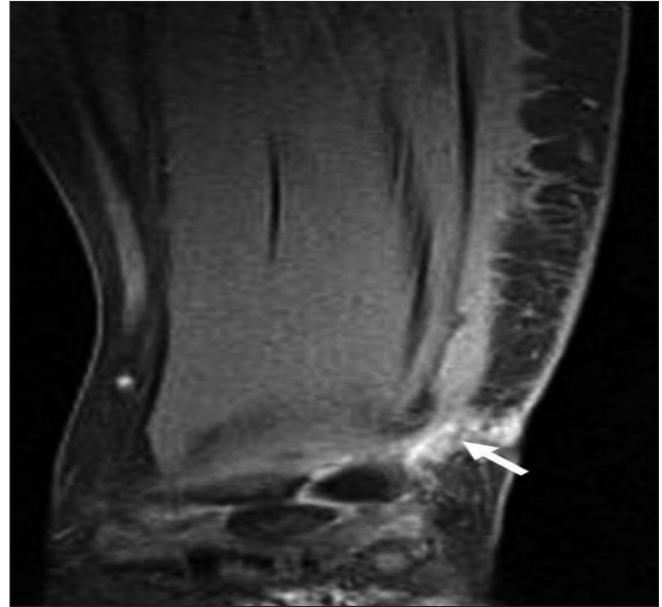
MRI of the right forearm. T1-TSE with fat suppression coronal images reveal fistula formation towards the surface of the skin, communicating with the ulnar bursa (→)
